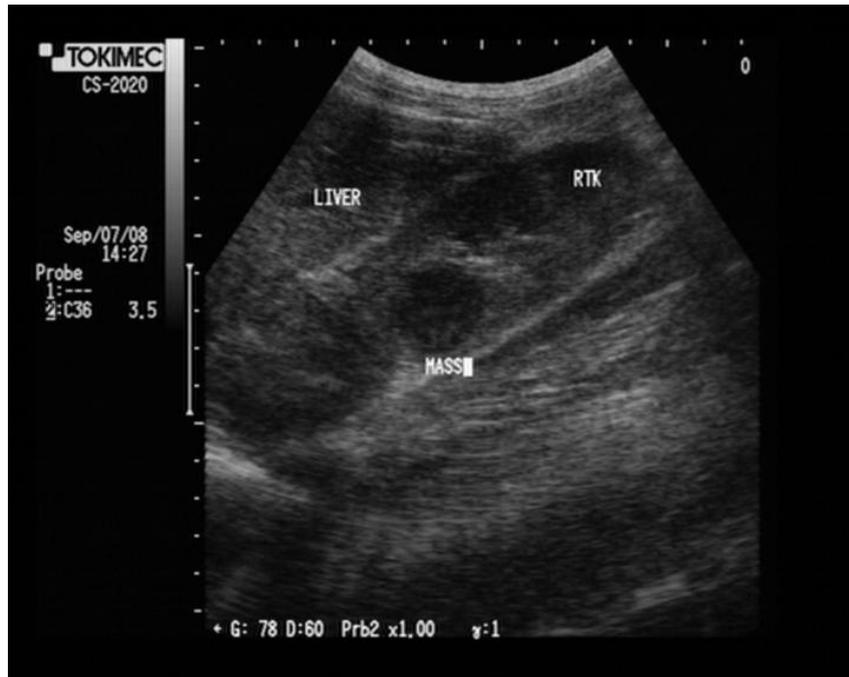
Longitudinal renal sonogram in TB patients; mid polar solid renal mass
